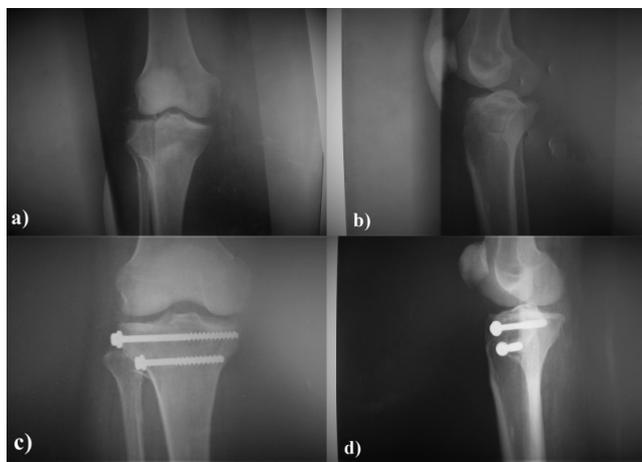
Tibial plateau Schatzker type I fractures treated with closed reduction and percutaneous screw fixation: Preoperative and postoperative appearance; a) anterior posterior, b) lateral radiography (respectively).
